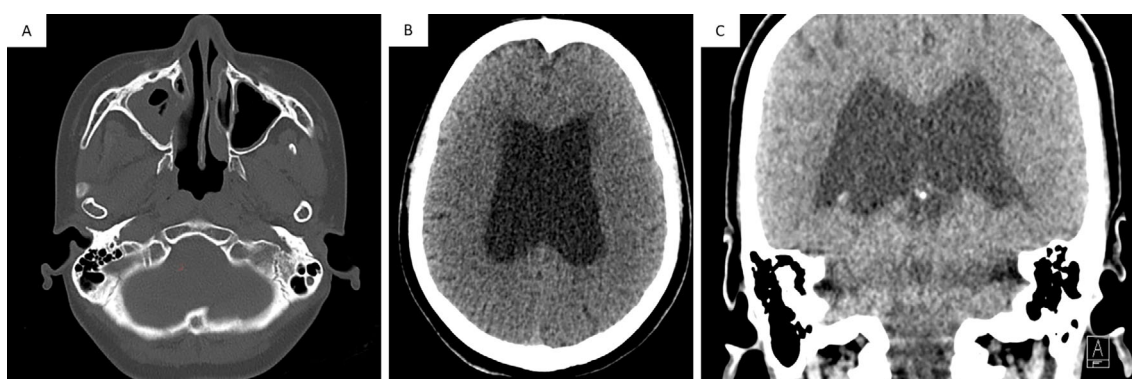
Sinus computed tomography images showing fluid retention in the right maxillary sinus (A) and enlargement of the lateral ventricles. (B) Axial view, (C) coronal view.
